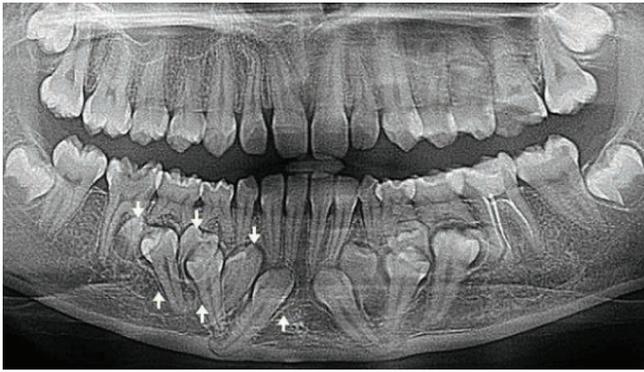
Orthopantomograph showing retained deciduous and impacted permanent and supernumerary teeth.
